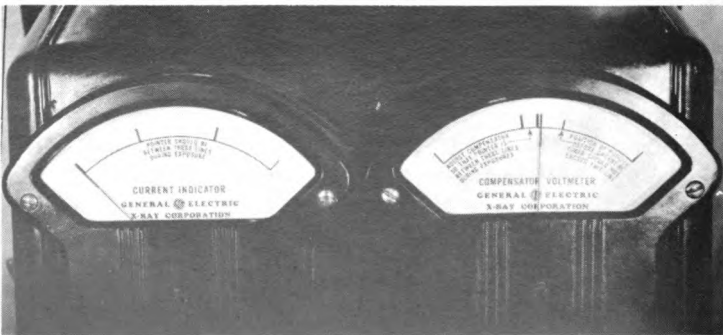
Current indicator and compensator voltmeter, with no electric current entering the X-ray tube. Instrument panel before generating X-rays.
